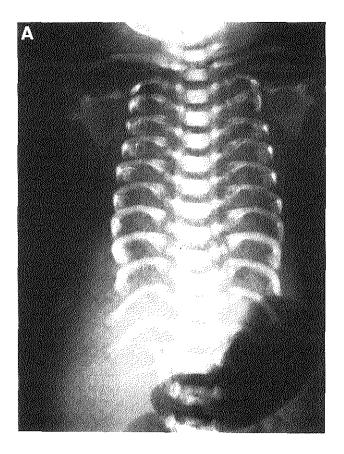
Radiographs of the thorax (A) and pelvis (B) of the second affected infant. Note (A) the handlebar clavicles, short horizontal ribs, (B) the square-shaped iliac bones, the medial spurs of both acetabular roofs and the presence of the proximal femoral ossification centers.
